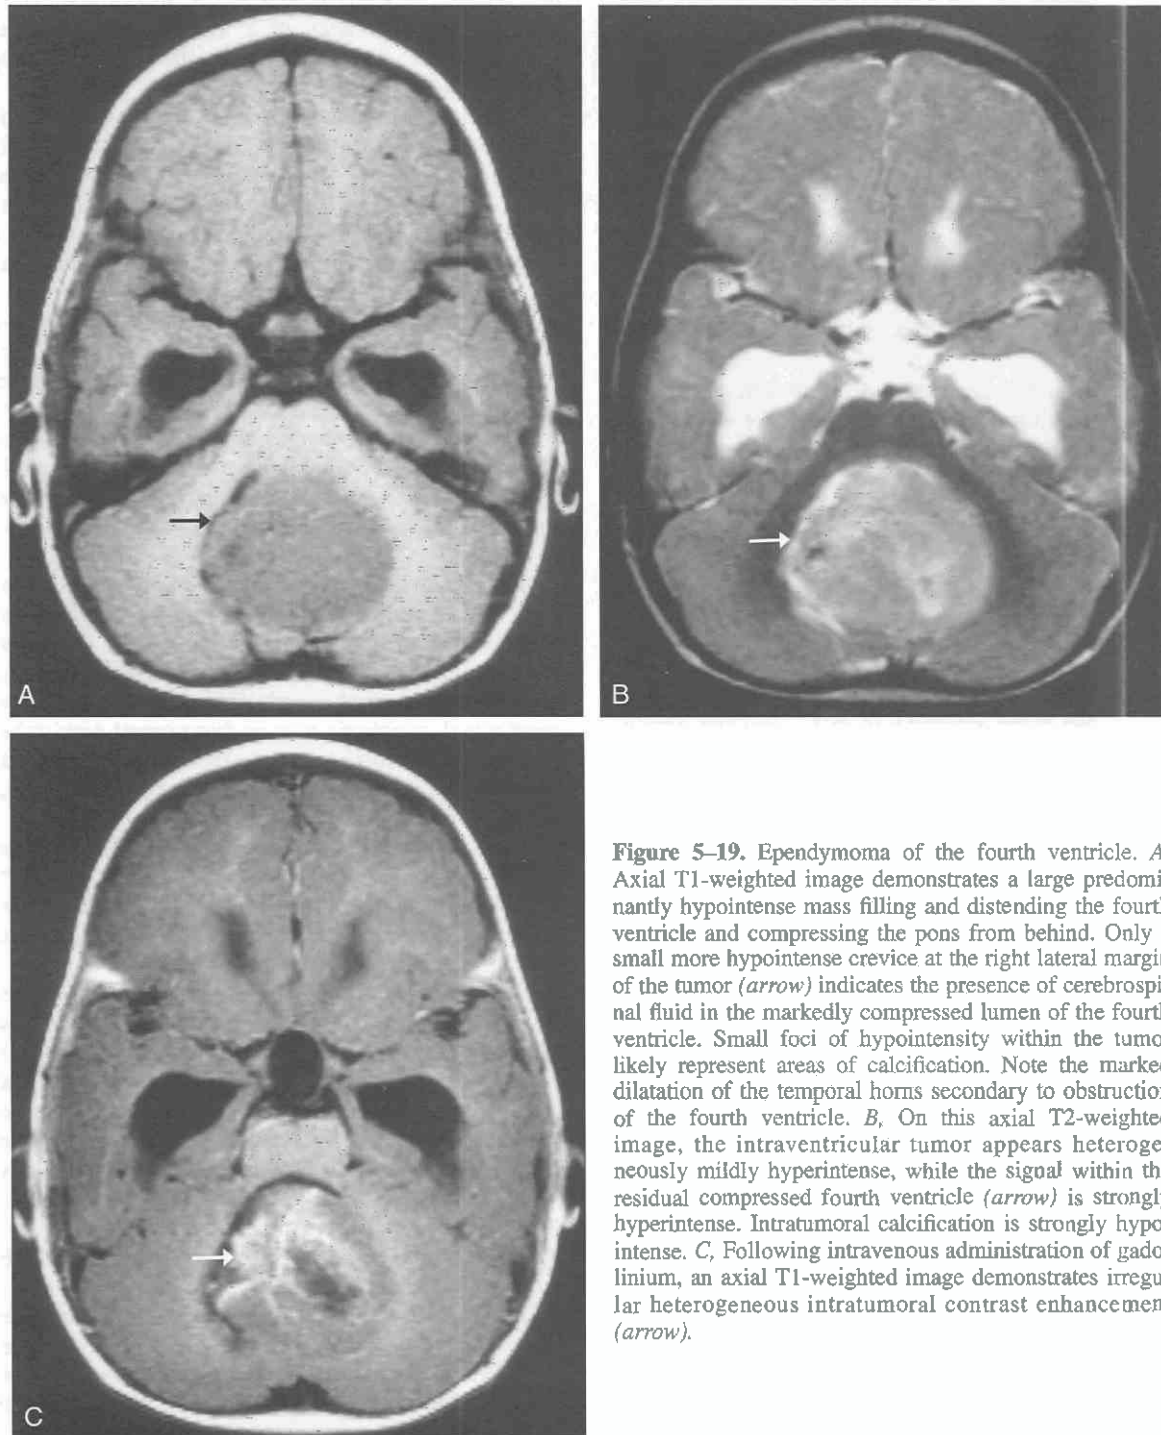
Ependymoma of the fourth ventricle. *A*, Axial T1-weighted image demonstrates a large predominantly hypointense mass filling and distending the fourth ventricle and compressing the pons from behind. Only a small more hypointense crevice at the right lateral margin of the tumor (arrow) indicates the presence of cerebrospinal fluid in the markedly compressed lumen of the fourth ventricle. Small foci of hypointensity within the tumor likely represent areas of calcification. Note the marked dilatation of the temporal horns secondary to obstruction of the fourth ventricle. *B*, On this axial T2-weighted image, the intraventricular tumor appears heterogeneously mildly hyperintense, while the signal within the residual compressed fourth ventricle (arrow) is strongly hyperintense. Intratumoral calcification is strongly hypointense. *C*, Following intravenous administration of gadolinium, an axial T1-weighted image demonstrates irregular heterogeneous intratumoral contrast enhancement (arrow).
